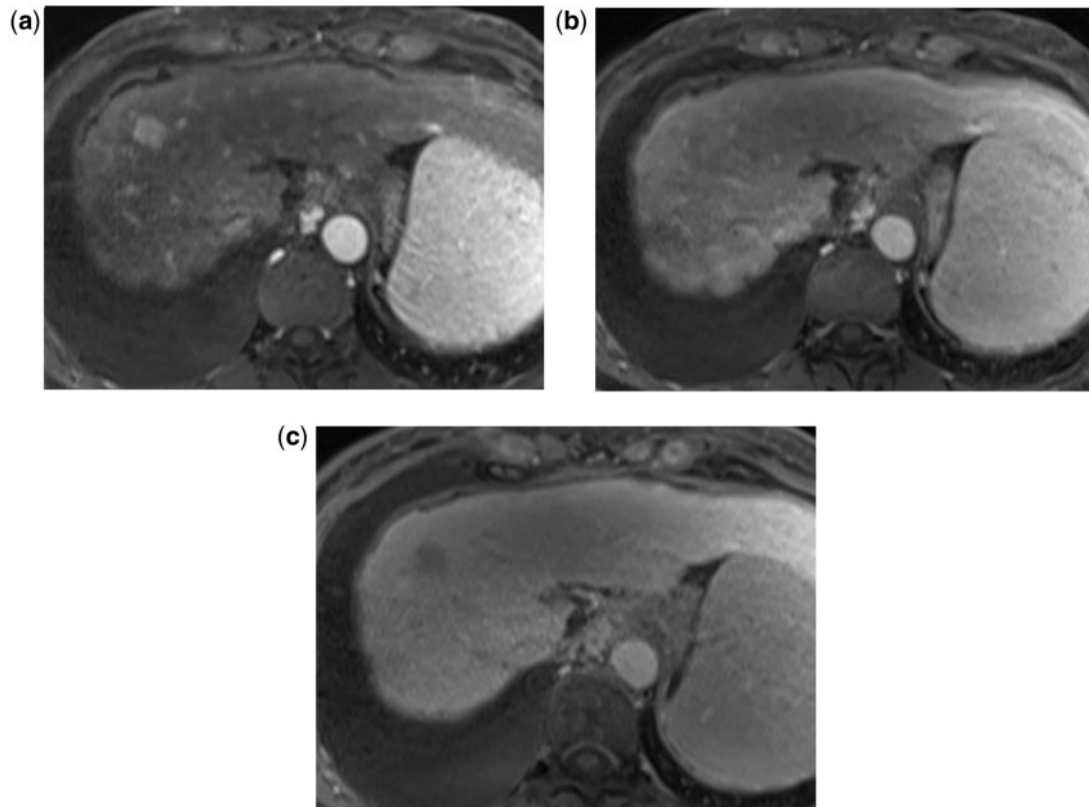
HCC: arterial hypervascularity and wash-out sign at MRI. HCC in the right lobe is hypervascular in the arterial phase (a), isointense in the venous phase (b) and shows wash-out to hypointensity in the equilibrium phase after 5 min (c). These imaging features are also pathognomonic for HCC. In principle, wash-out of HCC to hypointensity/hypoattenuation can be seen in the venous and/or equilibrium phases.
